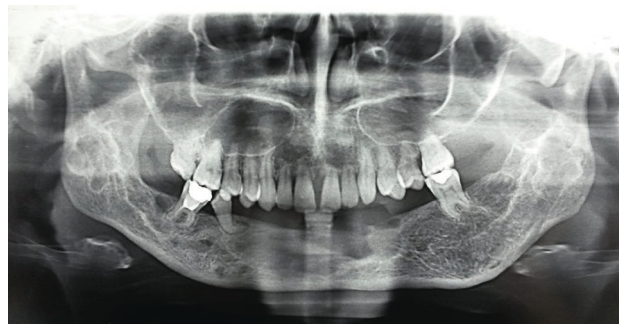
Orthopantomogram showing loss of teeth from the lower jaw.
